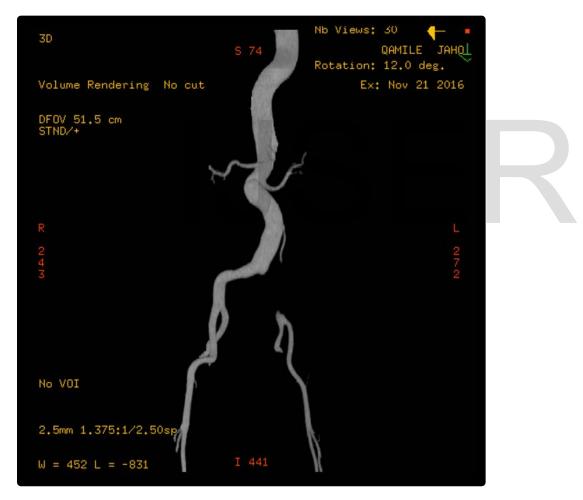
Angio CT showing thrombosis on the left iliac artery.
